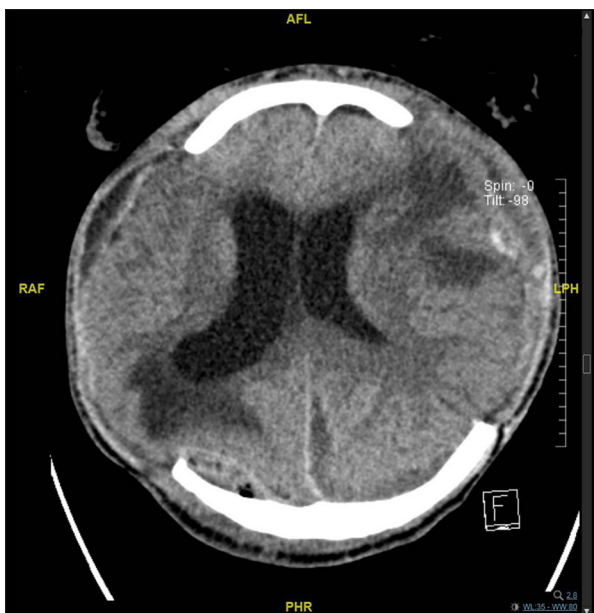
Computed tomography (CT) scan without contrast of the brain showing interparenchymal brain edema and active hydrocephalus with a midline shift.
